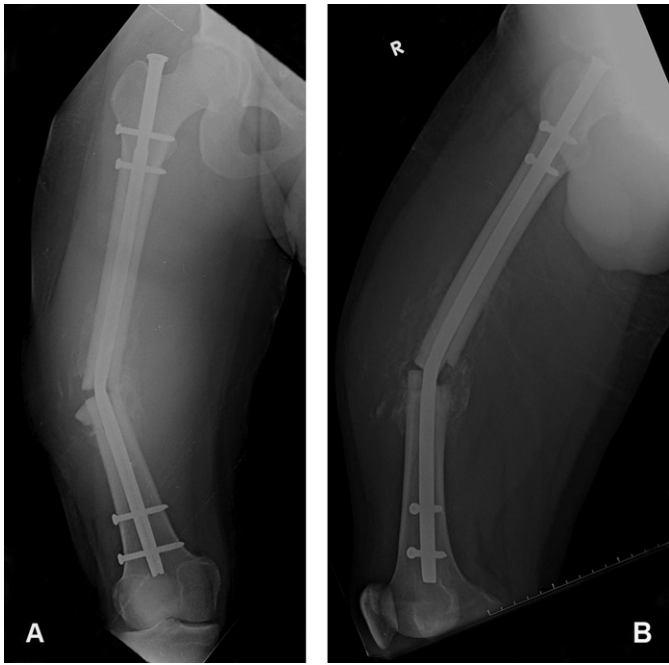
Radiographs showing the bent IM nail with 30° varus angulation in an AP view (A) and 30° anterior angulation in a lateral view (B).
